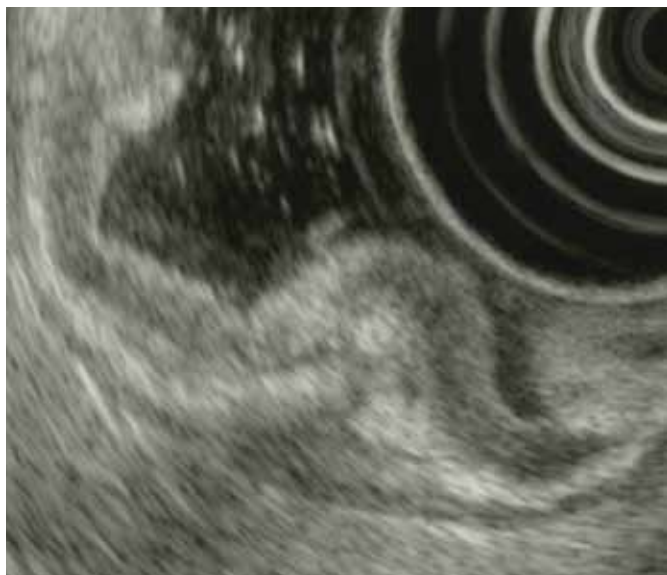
Endoscopic ultrasonography revealed marked thickening of the second and third layer, with a heterogeneous echoic pattern at the gastric folds of the body.
